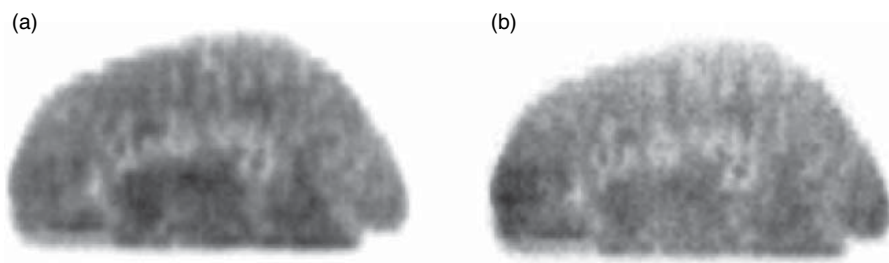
Example scanner types modeled in GATE: (a) SPECT system (IRIX-Beacon), (b) PET system (ECAT HR+).
